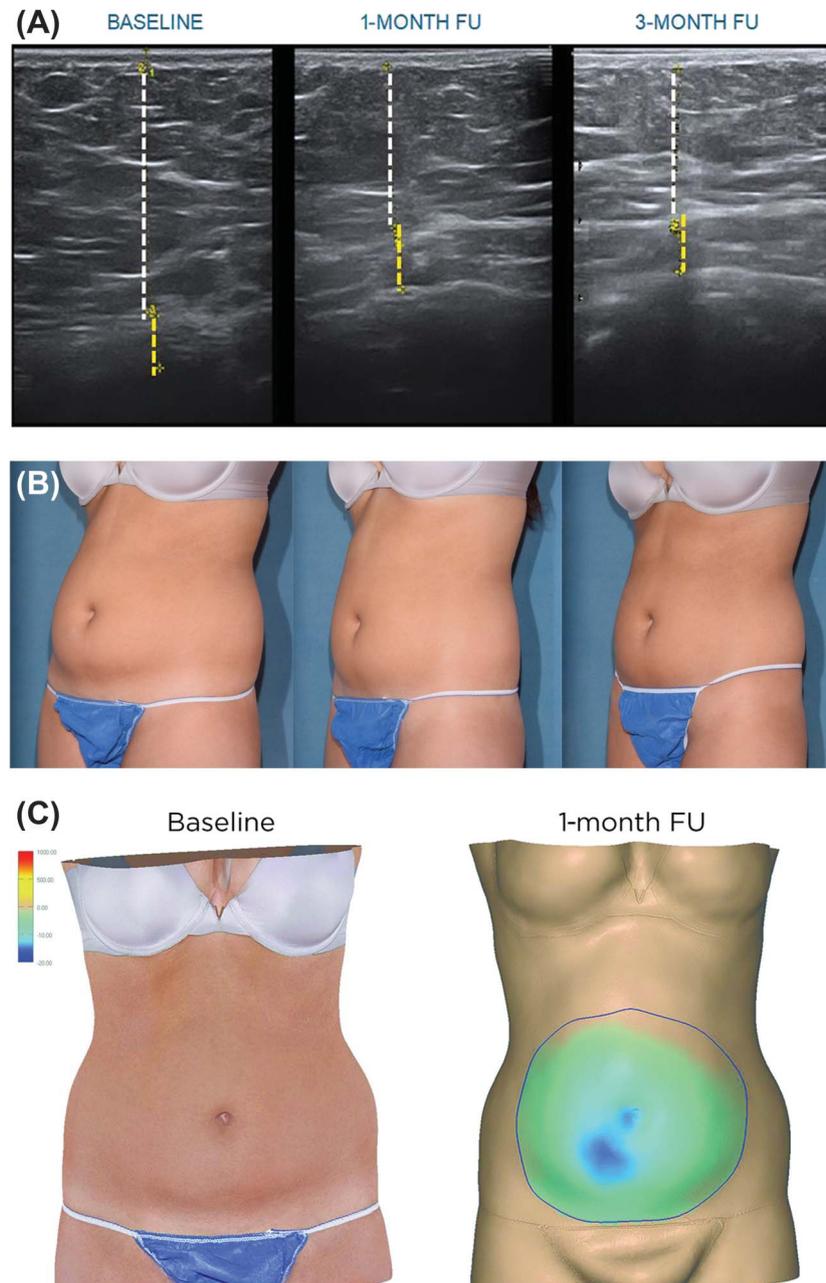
Example of results (Patient ID3, 24 years old). (A) Ultrasound images showing the subumbilical fat layer thickness. The white lines mark the fat layer, and the yellow lines represent the muscle layer. The fat layer thickness reduced by 10 mm (32%) from 31 mm at baseline to 21 mm at the 1-month follow-up and to 20 mm at the 3-month follow-up. (B) 2D photographs captured at baseline (left), 1 month (center), and 3 months (right) after treatments. (C) 3D images obtained at the baseline and at 1-month follow-up. The volumetric changes in the abdominal area are shown on the right image. Courtesy of Bruce Katz, MD. FU, follow-up.
